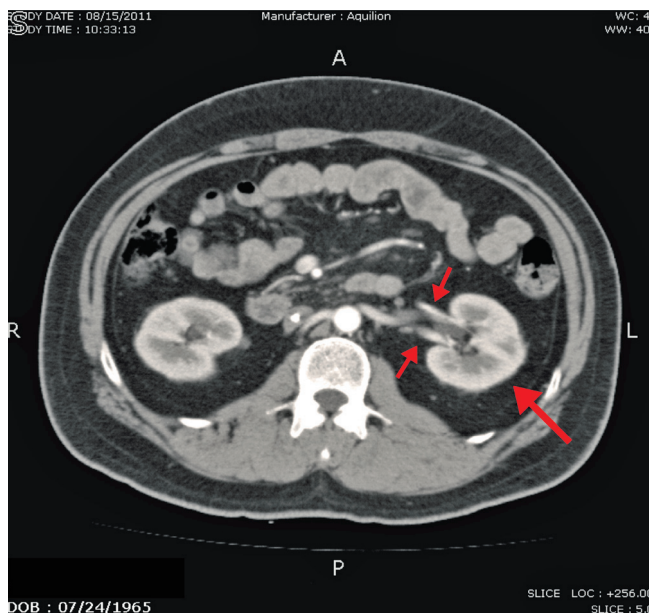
CT scan image showing the left renal artery dividing into anterior and posterior branches marked by the *smaller arrows*. The *larger arrow* signifies relative avascular area
